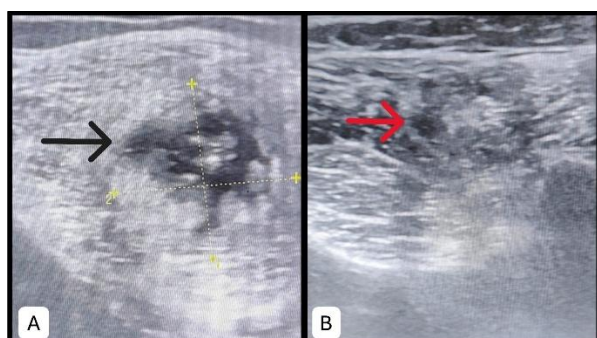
Ultrasonographic appearance of the cyst, A- at presentation [black arrow], B- 6 months following treatment [red arrow]
